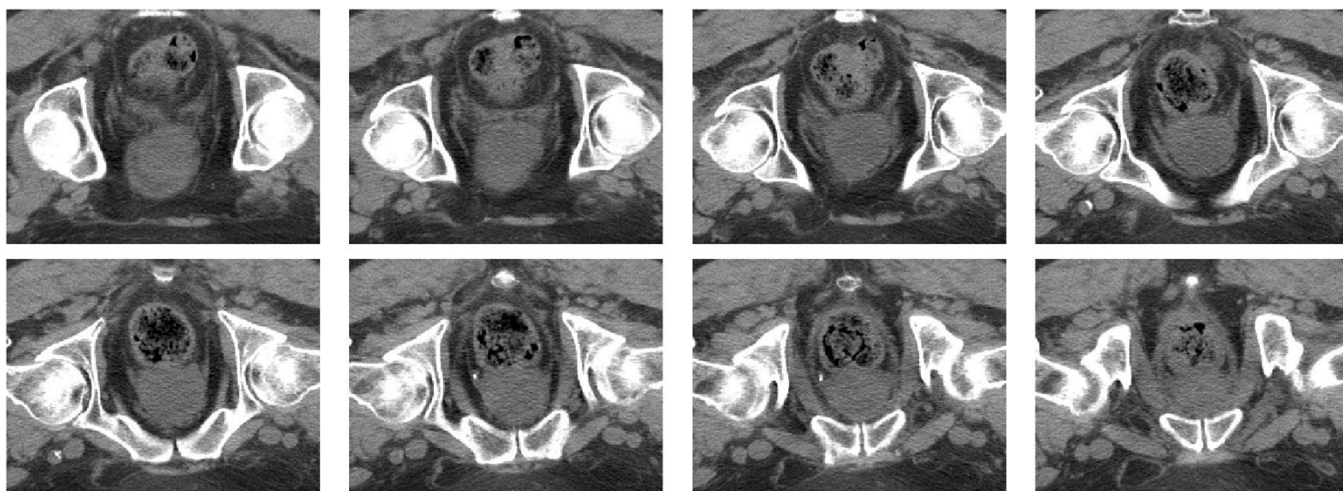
Evenly spaced axial slices of scan 6042, without segmentation. Eight sequential slices of the CT volume are displayed (out of the 35 total slices input to the algorithm.)
